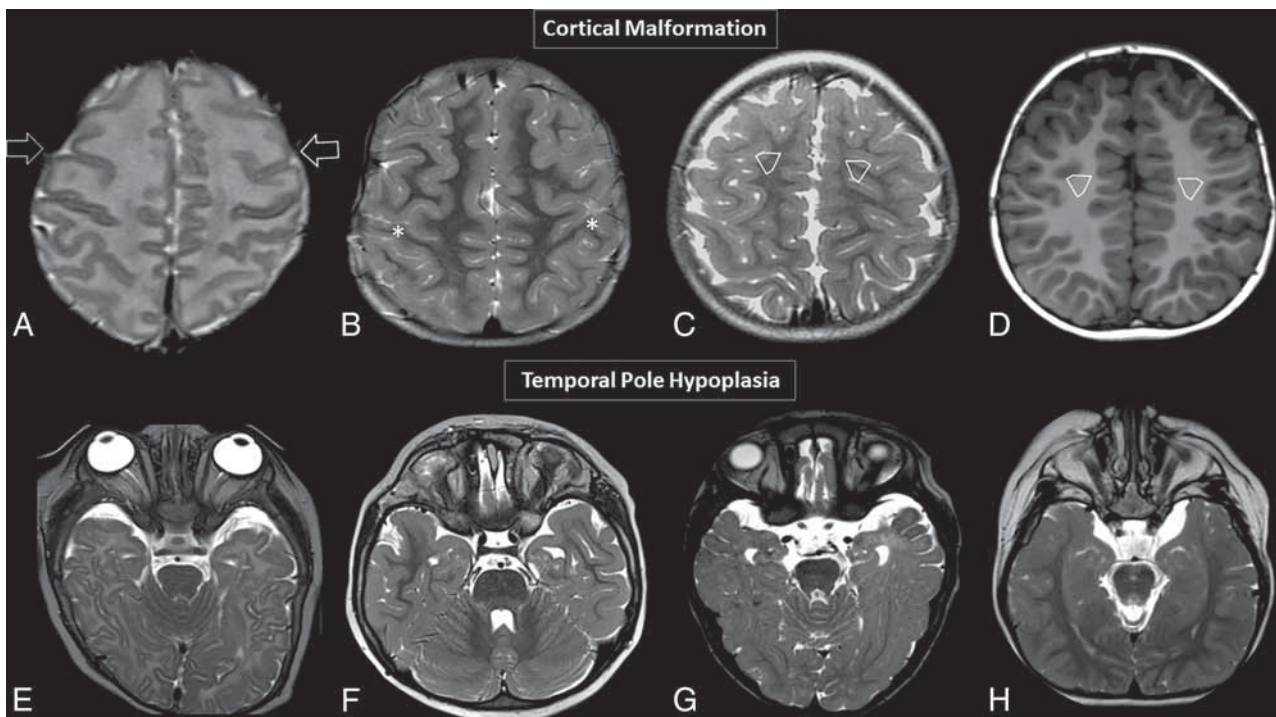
Brain MR images. Axial T2WI (A–C) and axial T1WI (D) showing 4 different patients with variable degrees of diffuse abnormal orientation and morphology of the gyri and sulci. Note particular abnormal morphology involving both frontal lobes (open arrows, A), a deformed perirolandic region (asterisks, B), and abnormal gyration of the medial frontal lobes in C and D (open arrowheads, C and D). Axial T2WI (E–H) shows 4 different patients with temporal pole hypoplasia.
